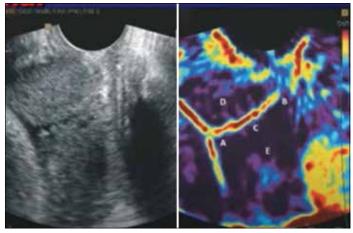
2D ultrasound and elastogram of the uterine cervix with soft cervical canal
